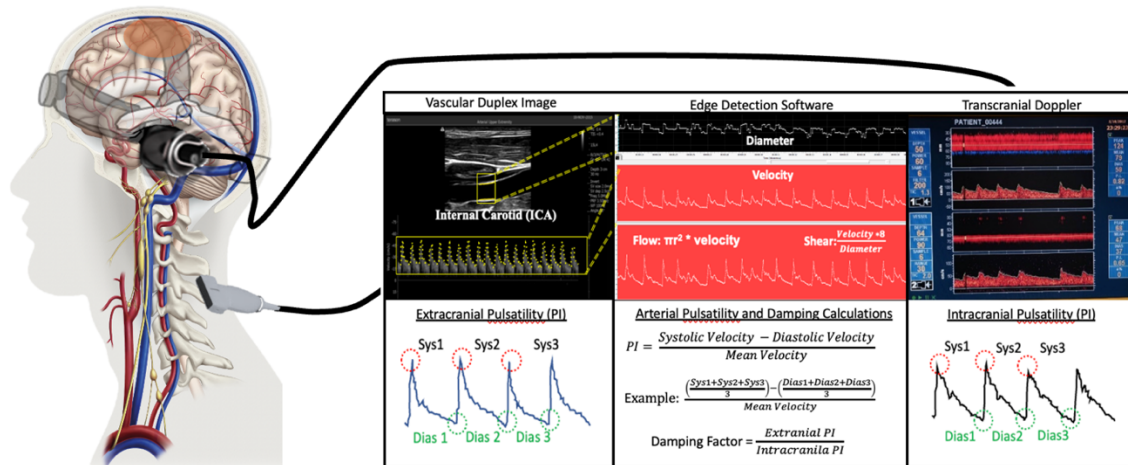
The left is a stylised imager of the brain and the insonated vessels Willie et al., (2014) adapted to include a transcranial Doppler ultrasound headpiece that supports the Doppler probe insonating the M1 segment of the middle cerebral artery accompanied by the velocity trace. The vascular Duplex ultrasound probe is insonating the internal carotid artery, accompanied by the B-mode image of the vessel (top portion) and the pulse wave trace (lower image). Using edge detection software continuous velocity and diameter of the ICA vascular walls help to reduce user bias when assessing the vessel. Both transcranial and vascular duplex ultrasound are able to measure pulsatility in the middle cerebral (PI_{MCA}) and internal carotid artery (PI_{ICA}) by dividing the systolic minus diastolic velocities by the mean velocities. Extra to intracranial damping factor is then calculated as the ratio of $PI_{ICA}:PI_{MCA}$.
